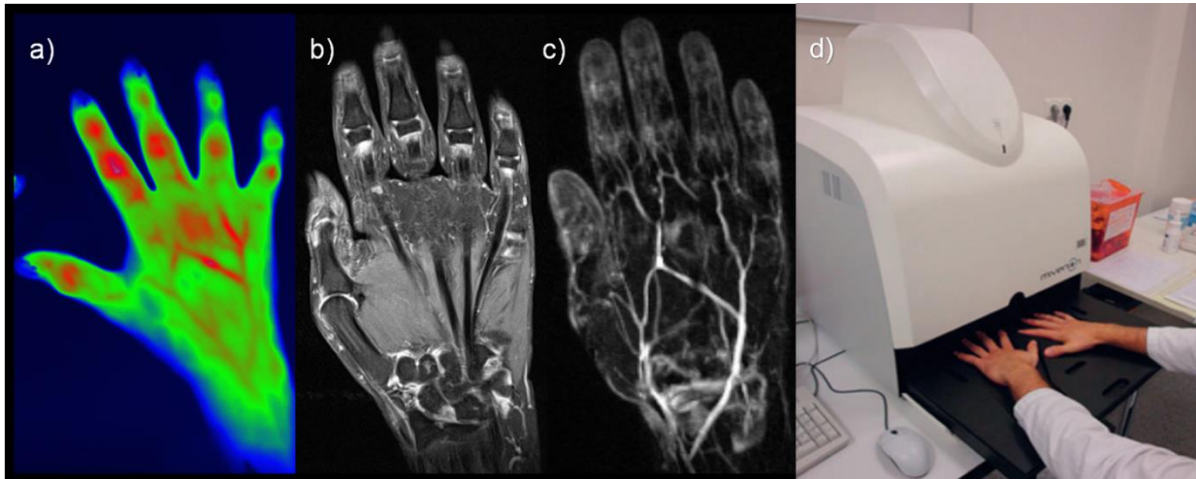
a) Image of the hand using the Xiralite X4 Rheumascan with focal hyperperfusion in the joints of MCP D III and IP, as well as PIP and DIP of II-V. b) c) Corresponding MR image revealing mild to moderate inflammatory signs in the same joints. d) Xiralite X4 Rheumascan imaging setup (Sievert, 2015).
